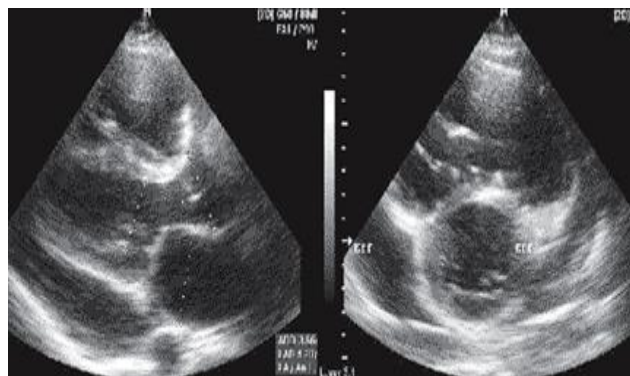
Ultrasound. Exudation in the pericardial cavity.
